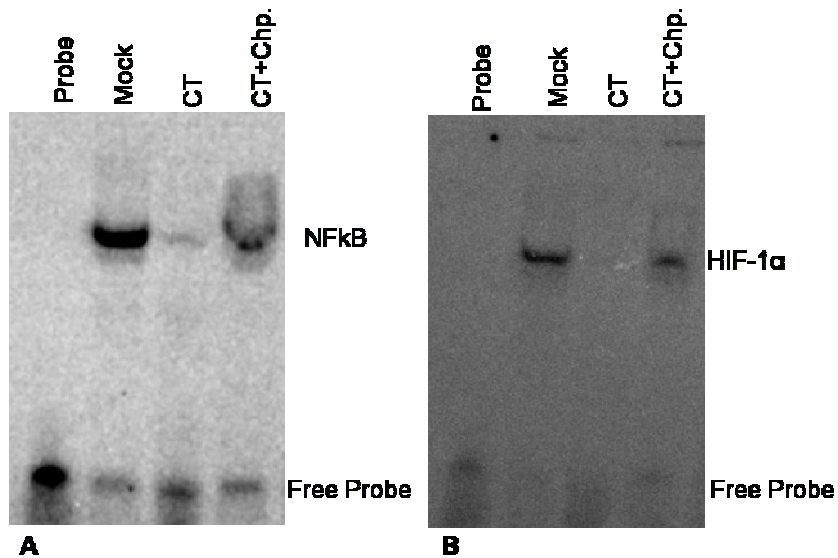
Effect of CT on NF- κ B and HIF-1 α activation:
